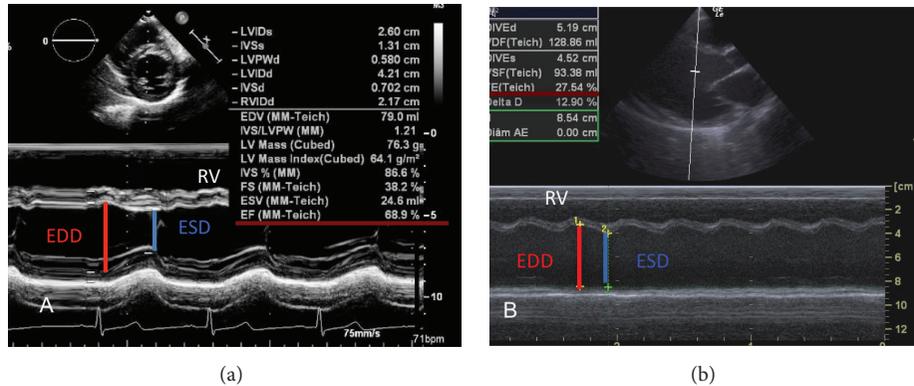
Calculation of left ventricular fractional shortening by the M mode. (a) Parasternal short-axis view in a patient with normal ejection fraction. (b) Parasternal long-axis view in a patient with viral myocarditis and cardiogenic shock, with reduced ejection fraction. EDD: left ventricle end-diastolic diameter; ESD: left ventricle end-systolic diameter; RV: right ventricle. FS = $(EDD - ESD) / EDD \times 100$.
